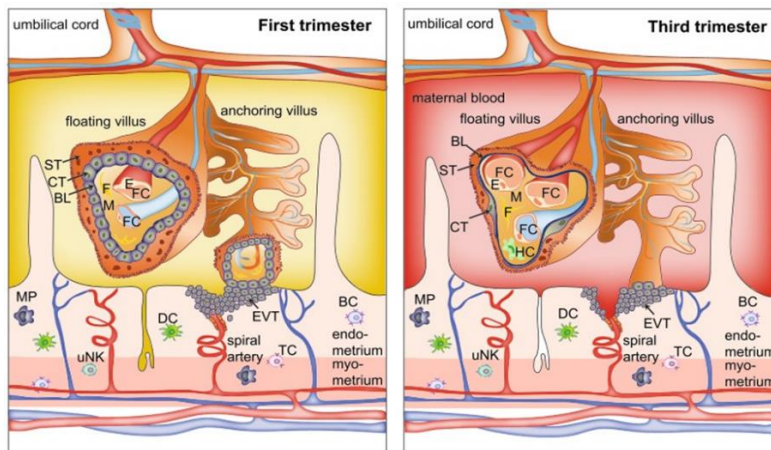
In the first trimester of human pregnancy, the villous trophoblast comprises two layers, a superficial layer of syncytiotrophoblast (ST) that rests in a second layer of cytotrophoblast (CT). Later in pregnancy, the cytotrophoblast becomes progressively sparser and the syncytiotrophoblast is mostly monolayered. Figure reproduced from Dugershaw et al.
